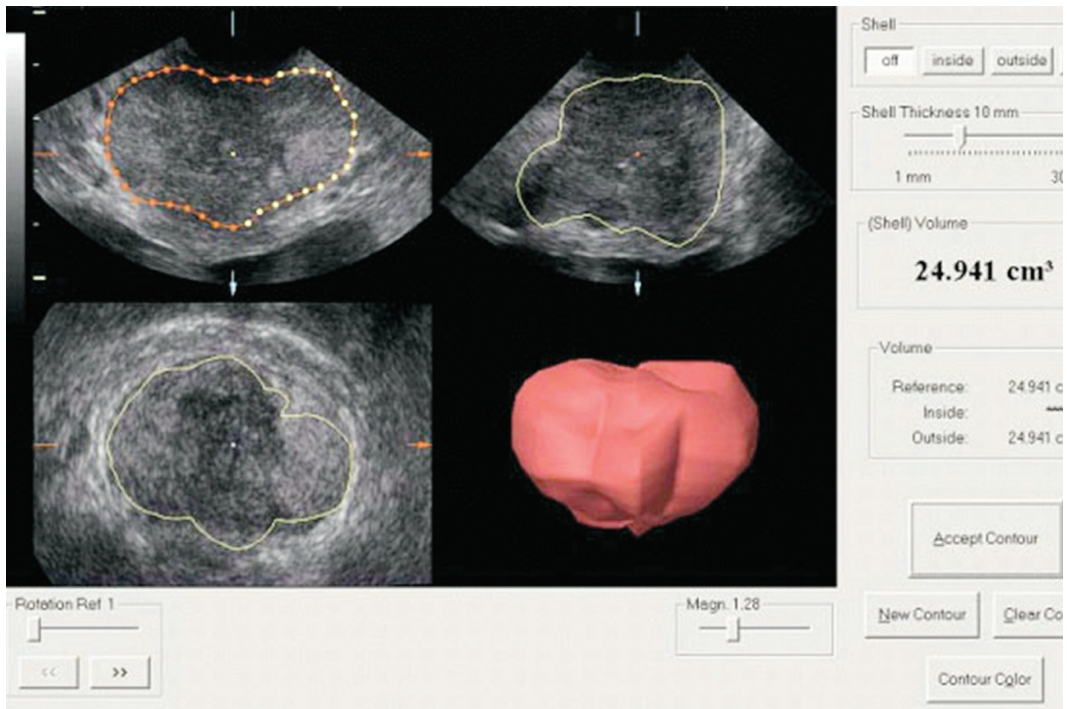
Three-dimensional ultrasound
